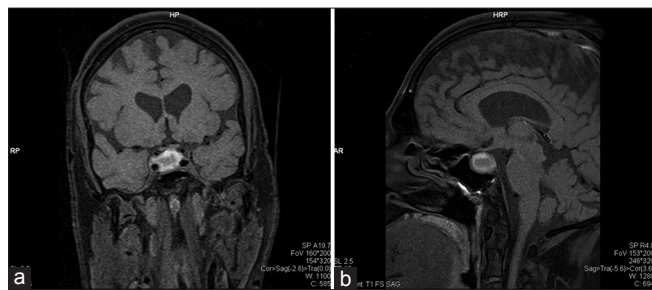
(a) MRI showing a sellar mass (2.2 × 1.3 cm in size) causing compression of optic chiasma, (b) MRI showing sellar mass compressing optic chiasma and invading cavernous sinus
